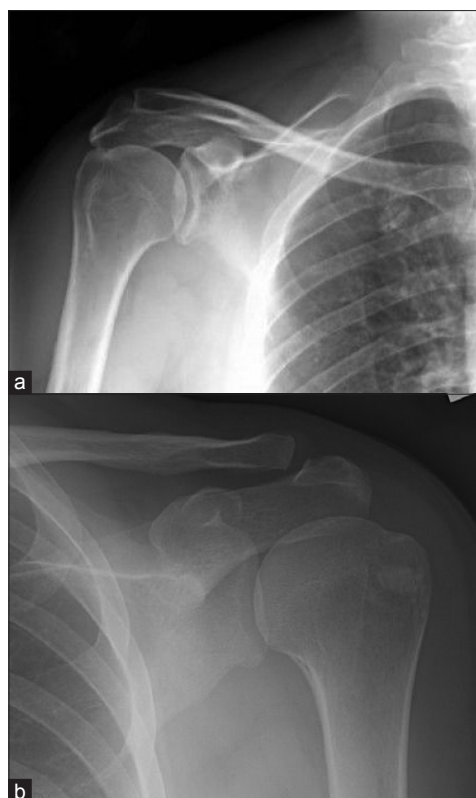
(a and b) Post-reduction X-ray showing congruent reduction of bilateral shoulder joint and anatomically reduced greater tuberosity fracture left side
